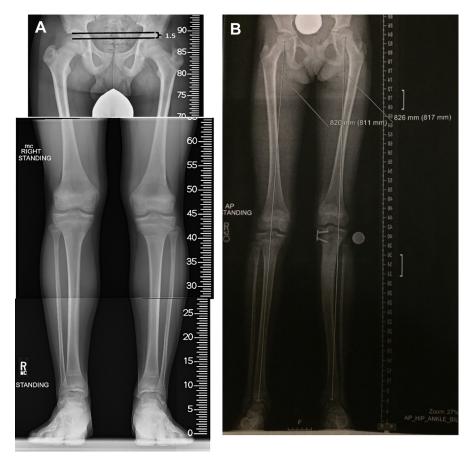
(*A*) Radiographs of a child with CNO show a 1.5-cm discrepancy between the total lengths of 2 legs (right > left) due to growth plate damage in left proximal tibia. (*B*) Radiograph of a child with CNO shows persistent angulation of left knee a year after stapling of the medial proximal tibia.
